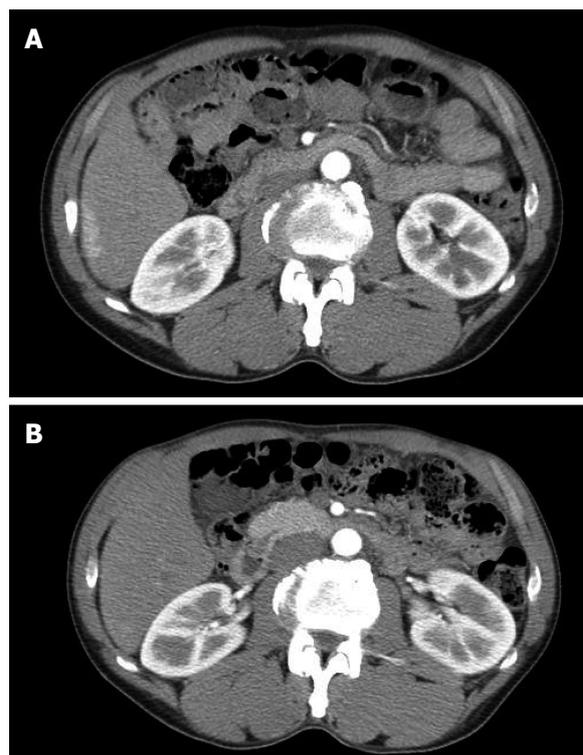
Abdominal computed tomography findings. A: Linear capsular enhancement of the inferior segment of the right lobe is visible on an arterial phase image; B: On an arterial phase image obtained 3 mo after treatment, the liver capsular enhancement over the right lobe has disappeared completely.
